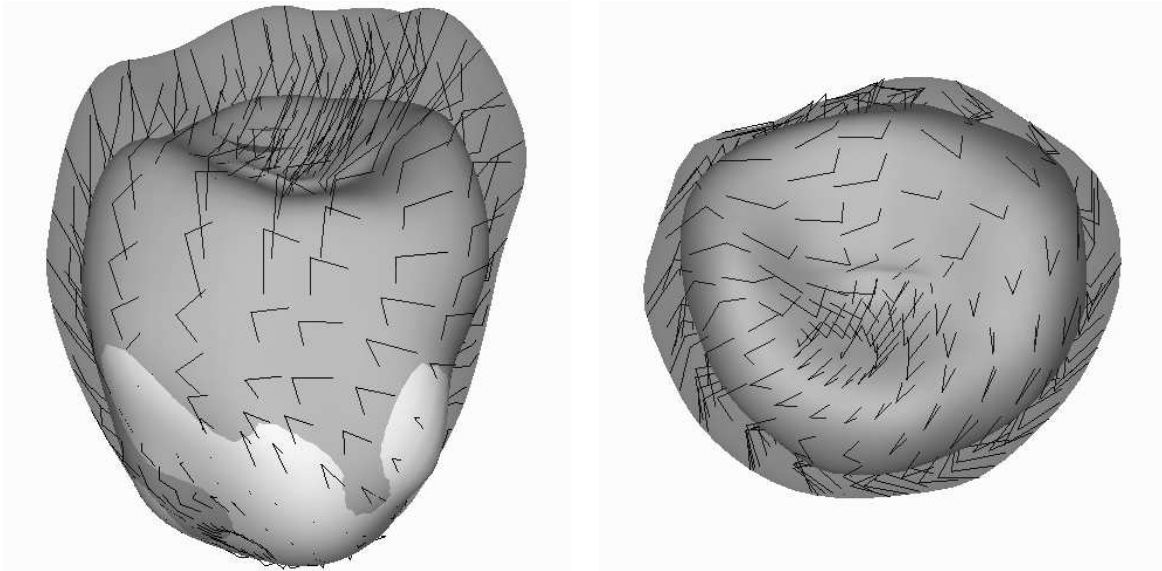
Trajectories of points on the model of the epicardium during a cardiac cycle from 2 viewpoints (SPECT). The two surfaces represent the models at end of diastole (dilation) and end of systole (contraction).
